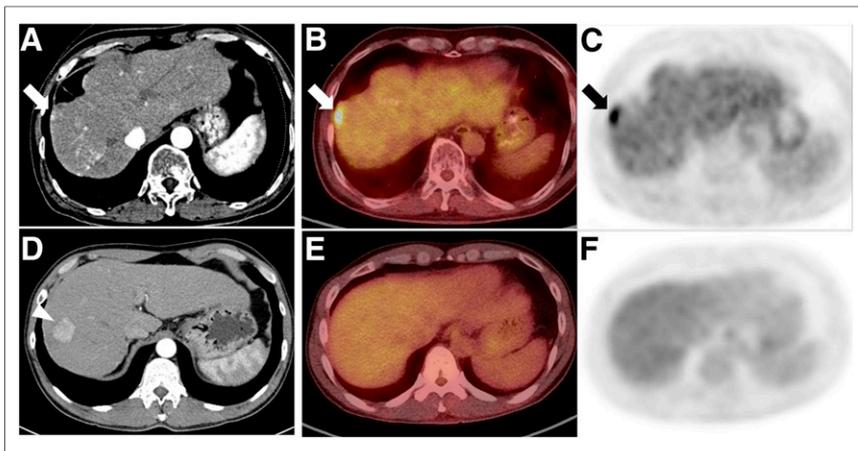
Images of representative cases. (A–C) 65-y-old man who presented with hepatic tumor (arrows) on enhanced CT (A), which showed high TBR_{IVCmax} (2.59) and UVP_{IVC} (18.91) on ^{18}F -FDG PET/CT (B) and PET (C). Although patient was within Milan criteria (3 tumors, with largest being 2.5 cm, and no vascular invasion), tumor recurred 16 mo after transplantation. (D–F) In contrast, 54-y-old man with hepatic tumor (arrowhead) on enhanced CT (D) showed low TBR_{IVCmax} (1.09) and UVP_{IVC} (13.54) on ^{18}F -FDG PET/CT (E) and PET (F). Although he was beyond Milan criteria (3 tumors, with largest being 3.3 cm), he exhibited no tumor recurrence until 41.7 mo after transplantation.
